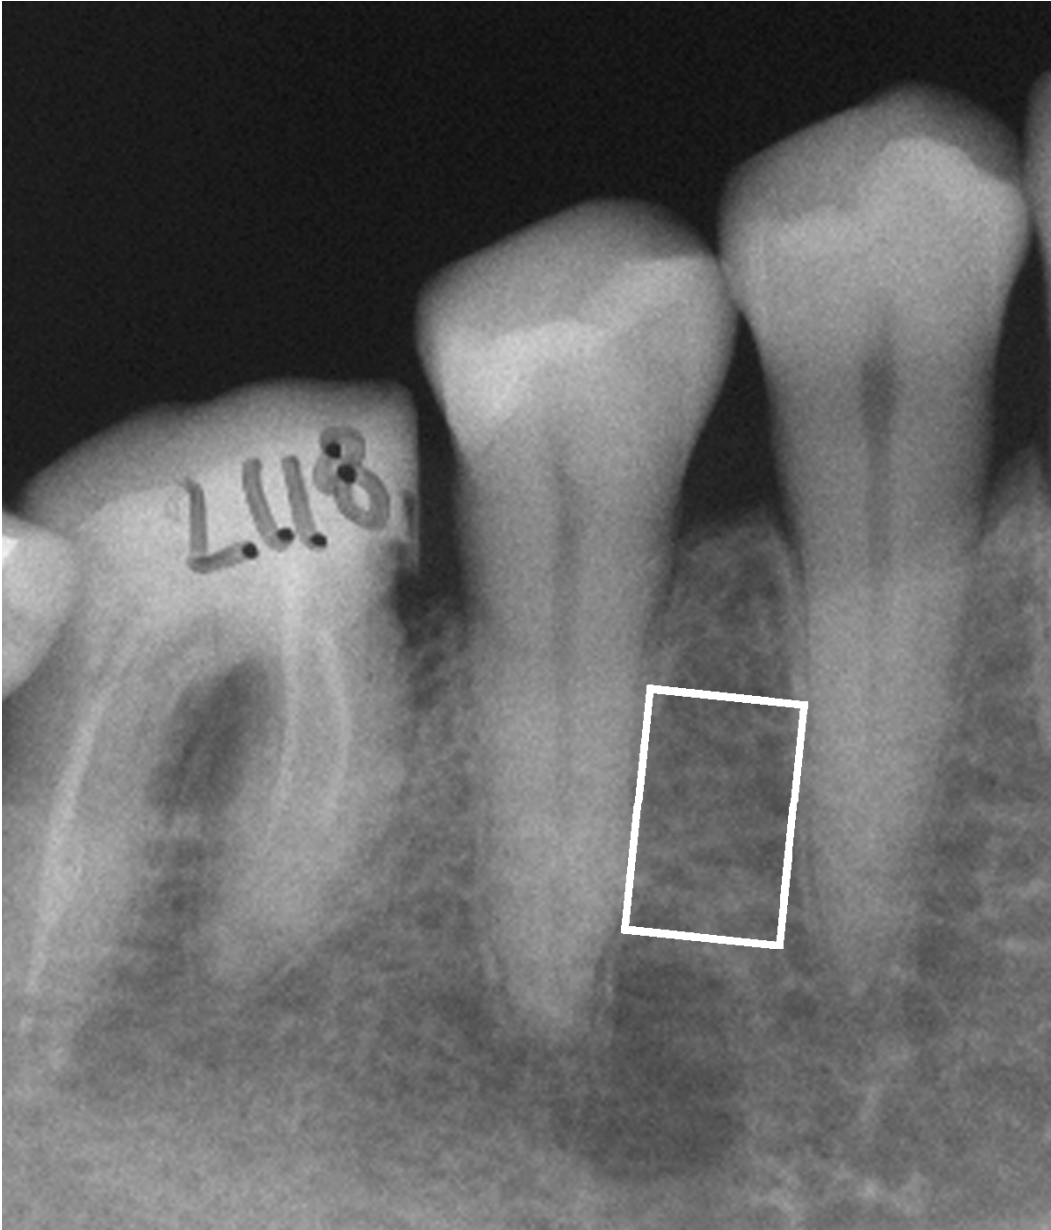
Radiograph of the right side of the lower jaw with region of interest 3.7 mm x 5.8 mm between first and second premolar. This is used to measure mean and standard deviation of the gray value (MEAN, SD).
